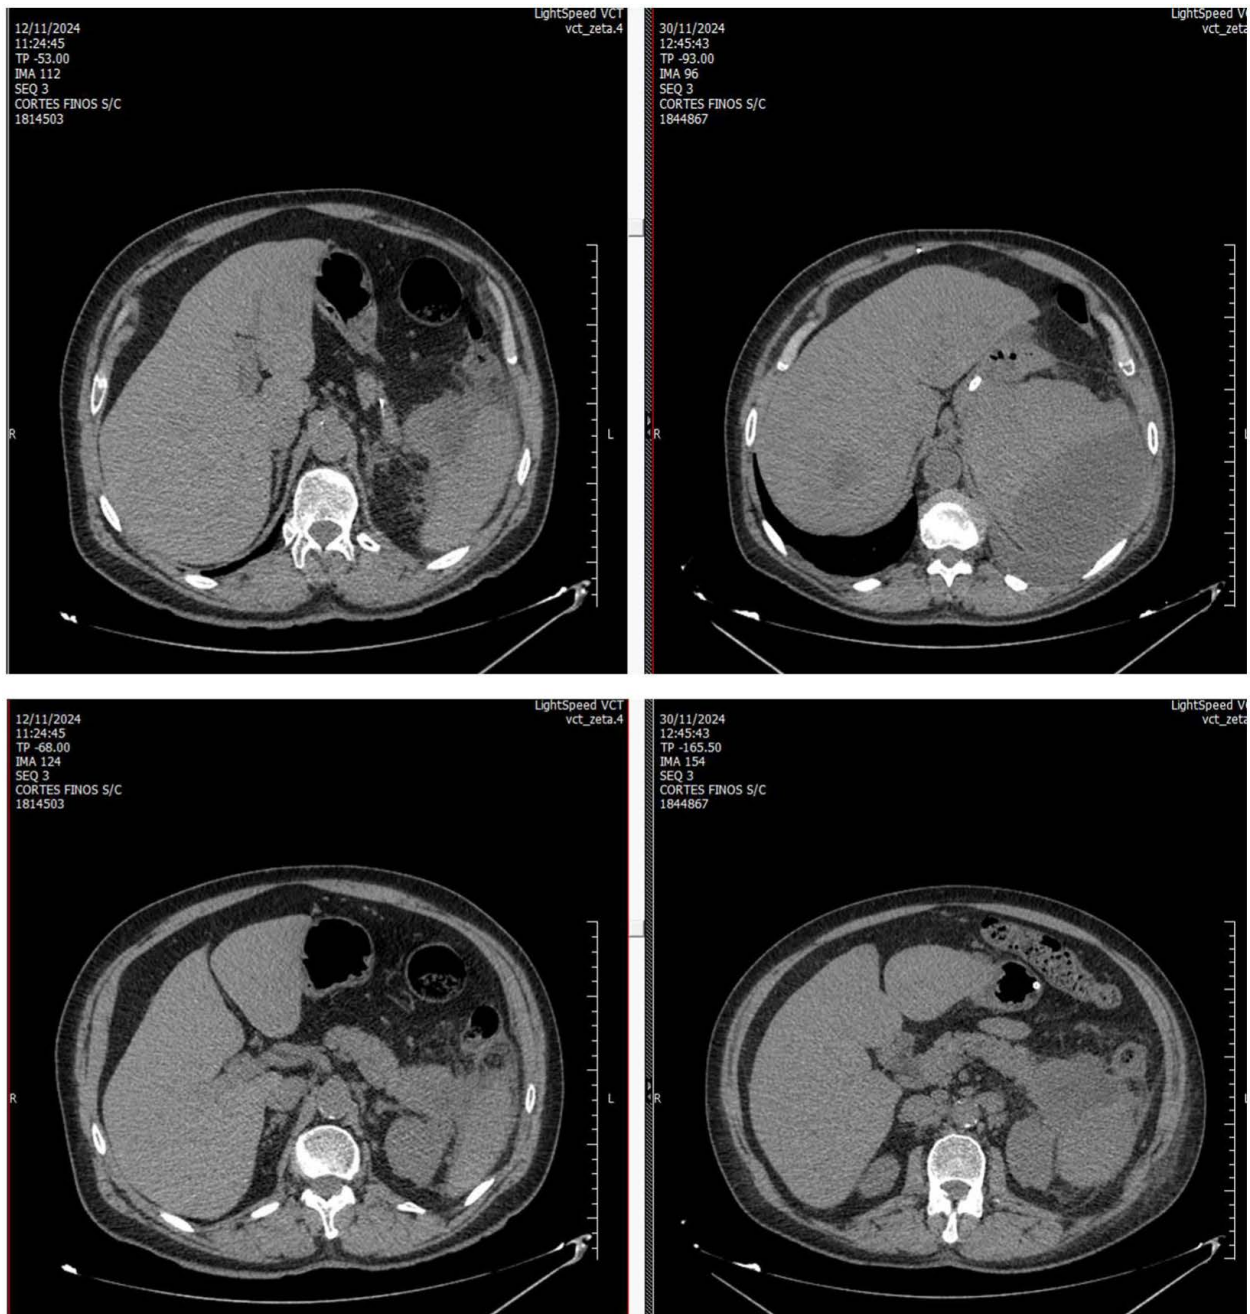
High-resolution CT scan done after hospitalization: both are arterial phase images from November/2024. There is evidence of progressive growth of a subphrenic fluid collection in the splenic region and moderate left pleural effusion, which prompted drainage of the splenic collection and thoracentesis
